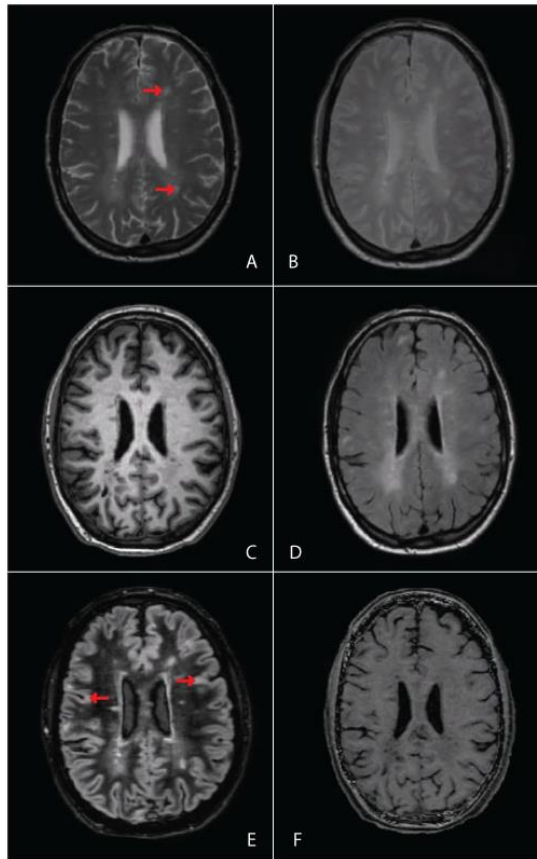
Examples of different MRI scans used to detect pathology in the MS brain. A) T2-weighted B) Proton density C) T1-weighted D) FLAIR E) DIR F) MTR. Red arrows indicate different types of pathology, visualised with different scans, i.e. white matter lesions on the T2-weighted scan (A), and cortical grey matter lesions on the DIR scan (E).
